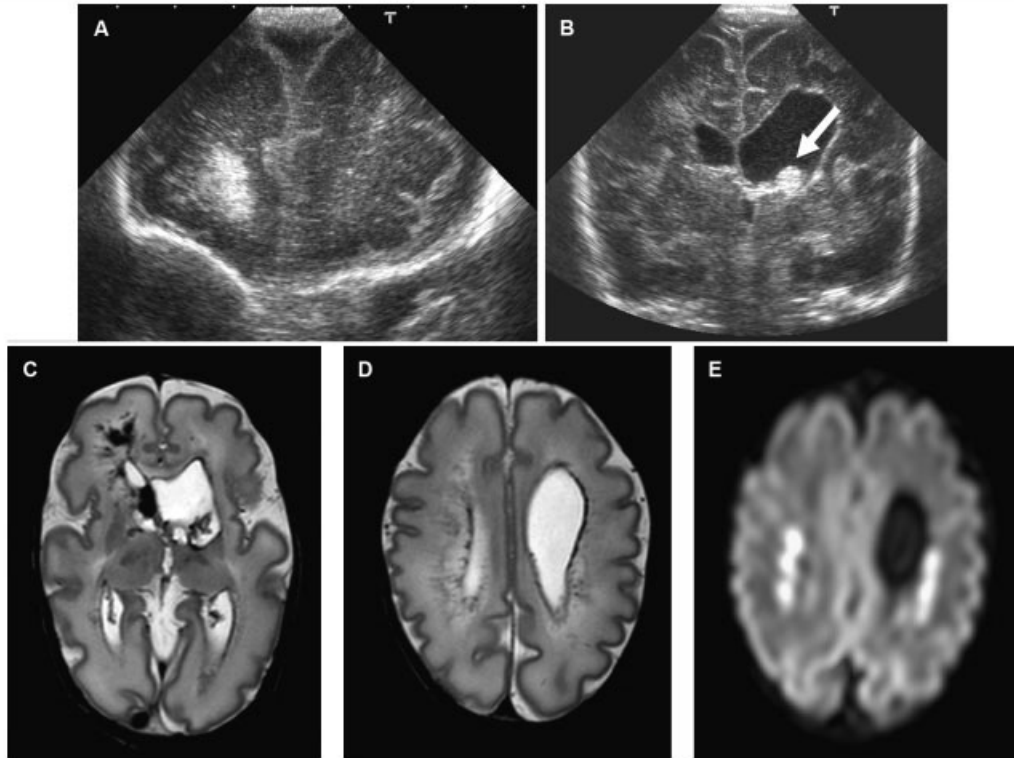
Day 1 cUS (A, B) and day 7 magnetic resonance imaging (C–E) of Patient 2. The coronal ultrasound images show an area of increased echogenicity in the right frontal periventricular white matter (A) and the large left-sided PC (B) with a small clot in the left lateral ventricle (arrow). The axial T2 spin-echo sequence images show the presence of hemorrhage in the right frontal lobe and the right lateral ventricle (C), high and low signal intensity adjacent to the lateral ventricles and the left-sided PC (D), and high signal intensity on diffusion-weighted imaging in the periventricular white matter (E).
